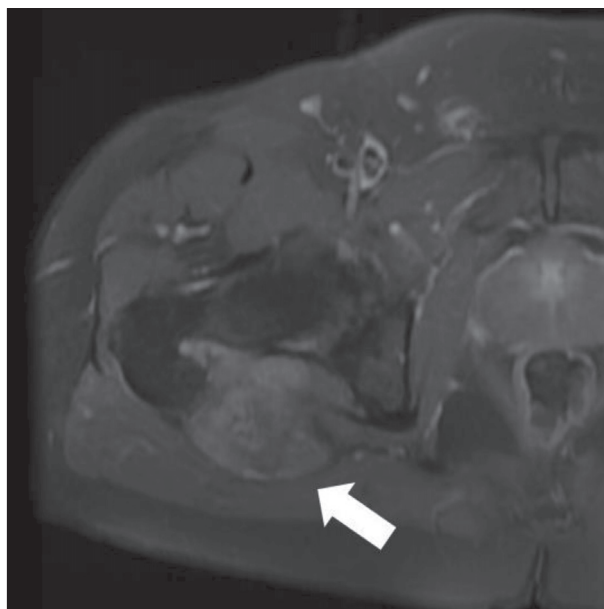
Case 3: a 49-year-old male with low-grade fibromyxoid sarcoma; pelvic magnetic resonance imaging demonstrated a sharp and lobulated contoured $8 \times 7 \times 3.5$ cm lesion extending between the right gluteal muscle fibers close to the trochanter major with heterogeneous enhancement; the sciatic nerve is encroached by the lesion (white arrow)
